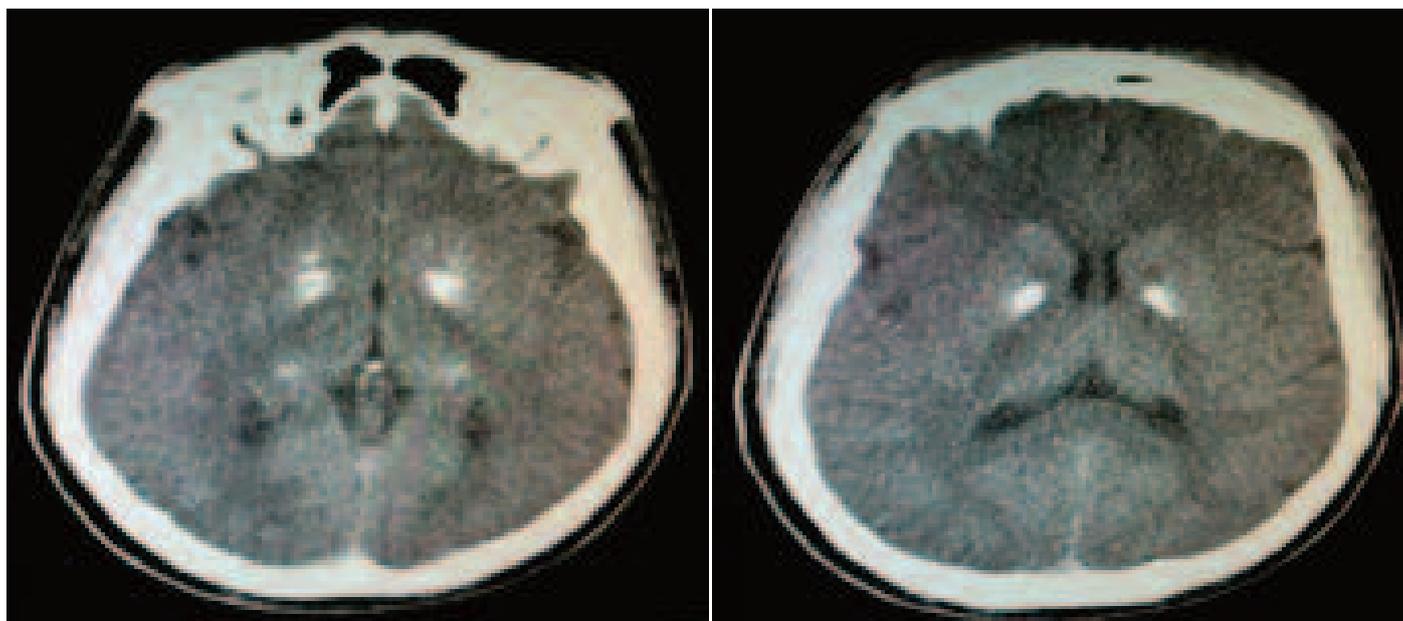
CT scans of patient 4, showing calcification of the bilateral basal ganglia and caudate nucleus.
